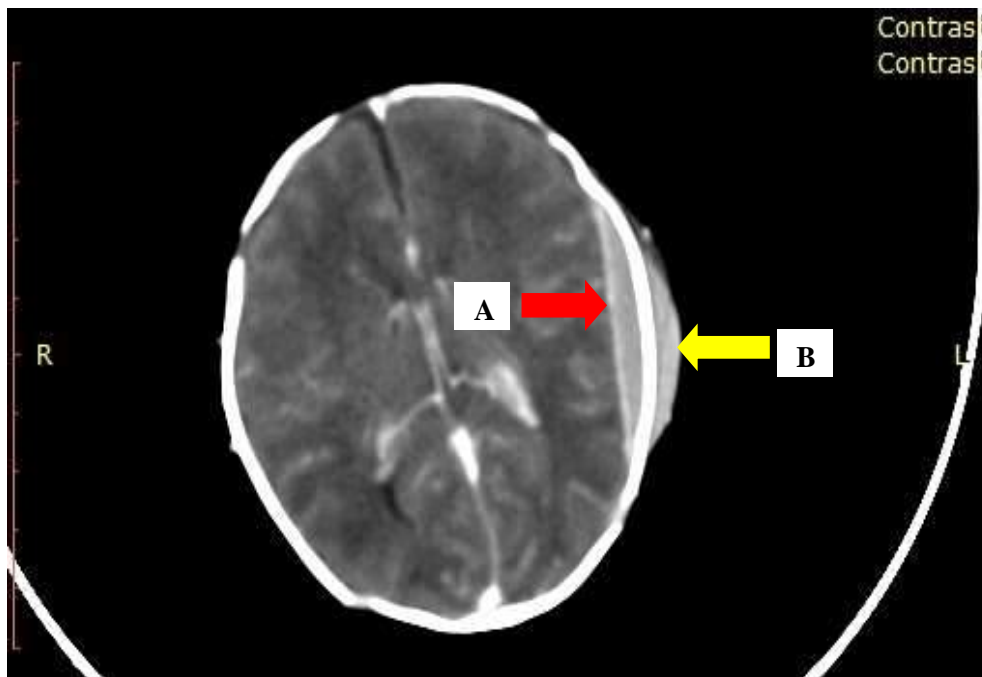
Axial contrast CT brain image showing left Parietal extra-axial Arrow A and subgaleal hematoma Arrow B
